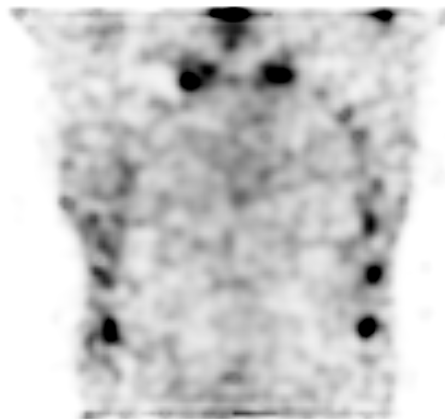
A noisy bone SPECT measurement with stripe artifacts (bottom and top). We can also see, that it is really hard to quantitatively measure the quality of medical images about real patients. It is also very important that we cannot prepare for all failures, such as the phenomenon shown in the picture.
